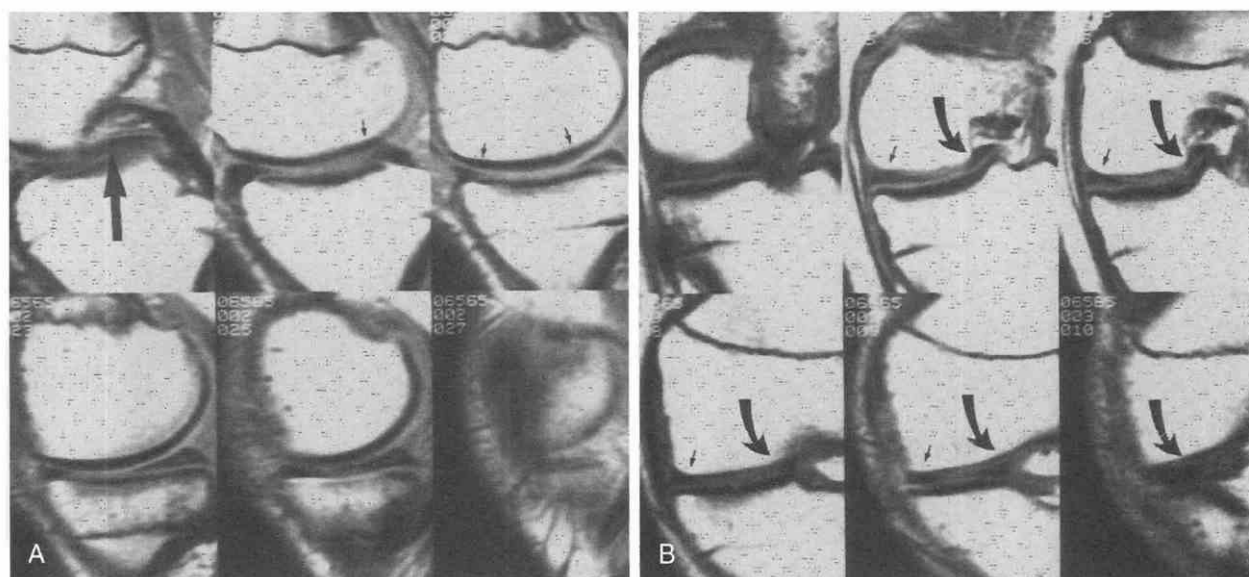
Bucket-handle tear. A, Sagittal T1-weighted images show a bucket-handle tear of the medial meniscus. The central portion is displaced into the intercondylar notch (*large arrow*). Note the distorted size and shape of the peripheral portion (*small arrows*). B, Coronal T1-weighted images show the irregular periphery (*small arrows*) and the displaced central portion (*curved arrows*).
